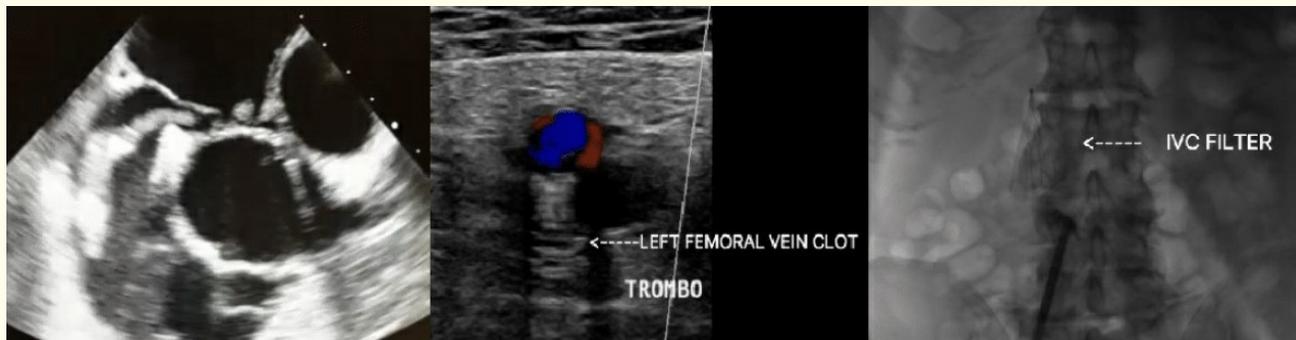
A: Echocardiogram revealing two blood clots communicating through a patent foramen ovale, B: Doppler ultrasonography of lower limbs was revealing vein thrombosis, C: Inferior Vena Cava Filter in place.
